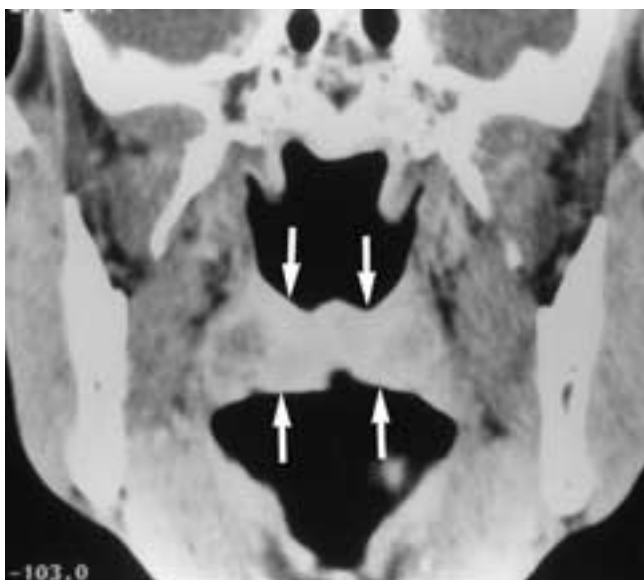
Coronal CT scan of a soft palate carcinoma demonstrates diffuse enlargement of the soft palate due to an infiltrating carcinoma (*arrows*).
